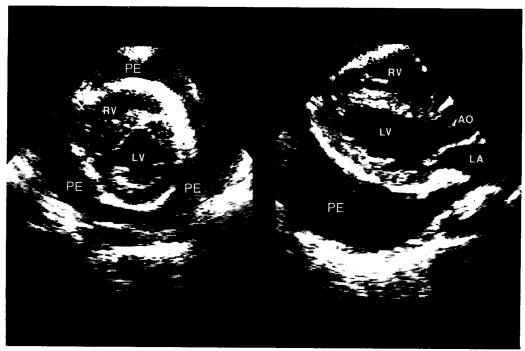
2D-echocardiographic images. Left-parasternal short axis view in the plane of the papillary muscles. Right-peristernal long axis view PE = pericardial effusion; LV = left ventricle; RV = right ventricle; LA = left atrium; AO = aorta.
